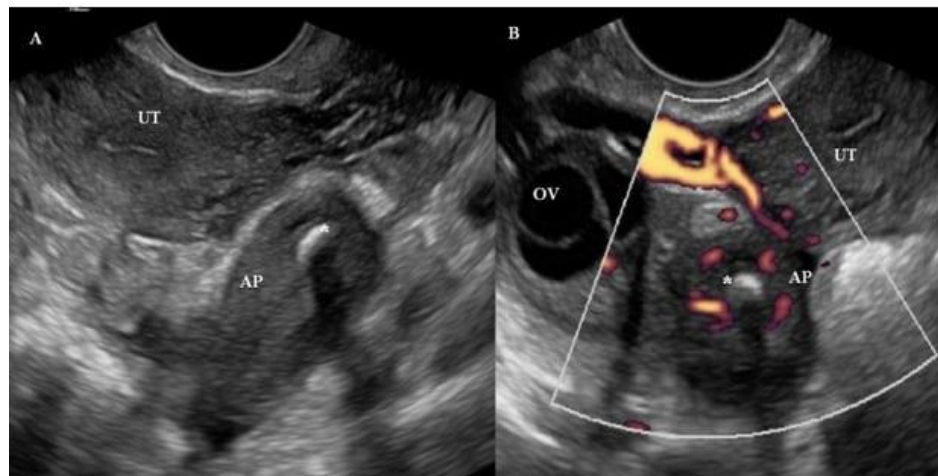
26-week gestational abdominopelvic ultrasonography during pregnancy
